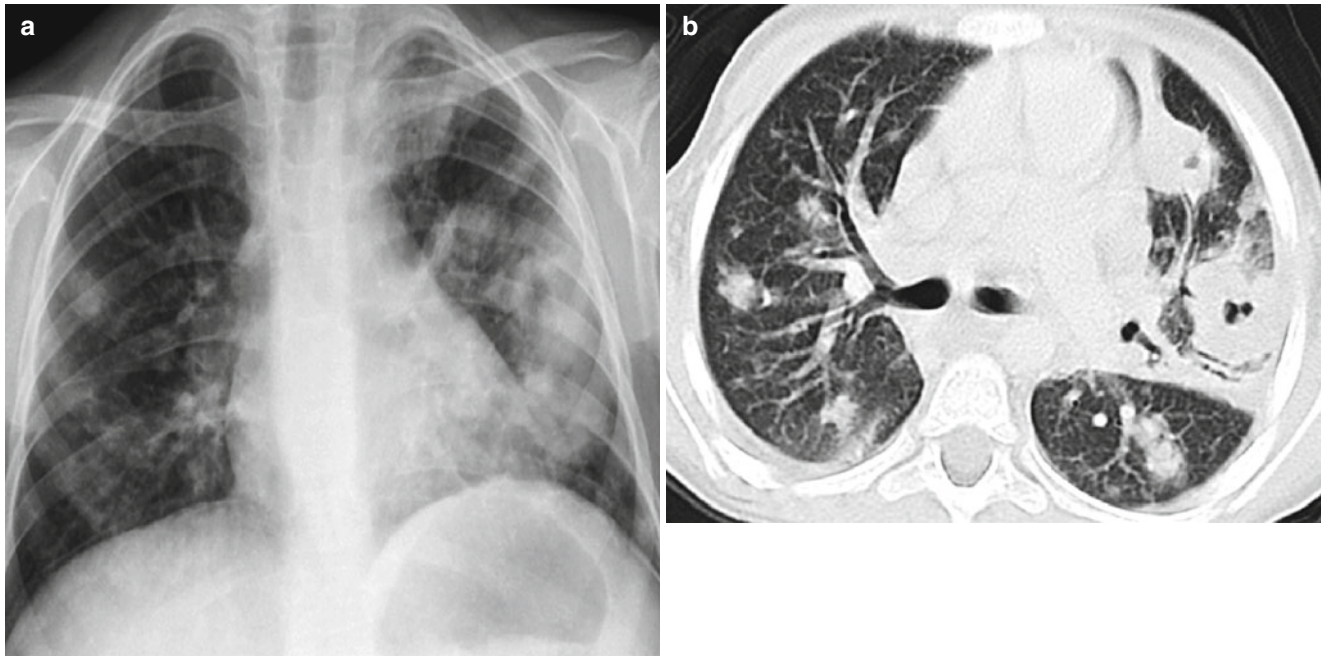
Staphylococcal abscess. A 9-year-old boy with chronic granulomatous disease with persistent fever had a chest x-ray (a) showing multiple rounded opacities in both lung fields. Axial CT scan
